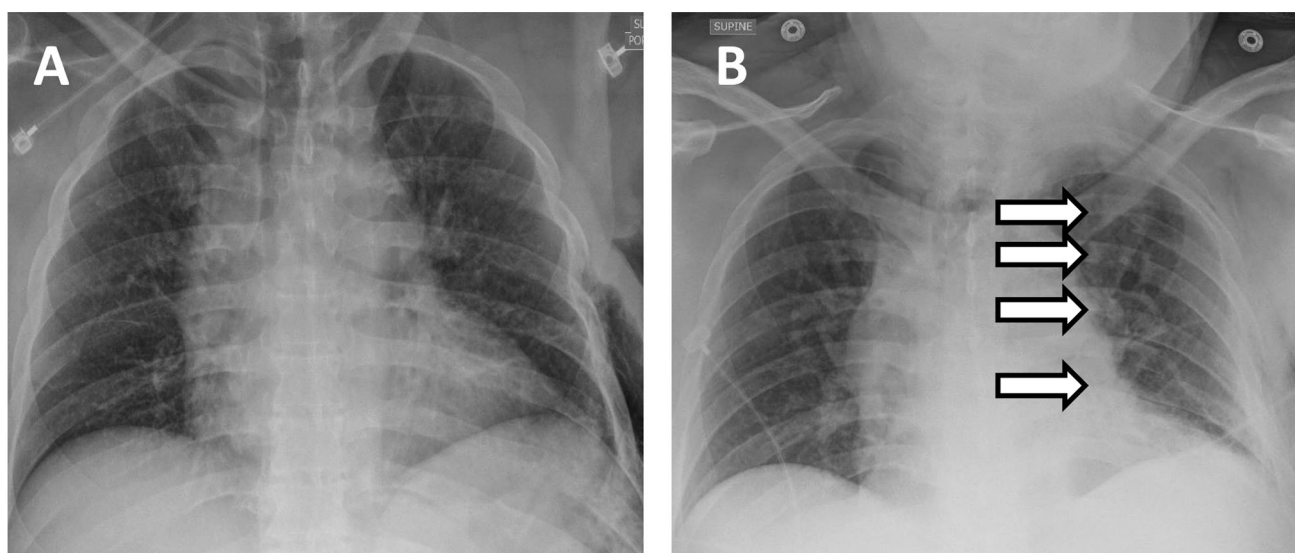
Initial chest x-ray of a 55-year-old male who sustained left 4–9 rib fractures which were initially nondisplaced (a). Chest x-ray of the same patient 24 h post admission to the ICU (b). Arrows indicated the interval displacement
